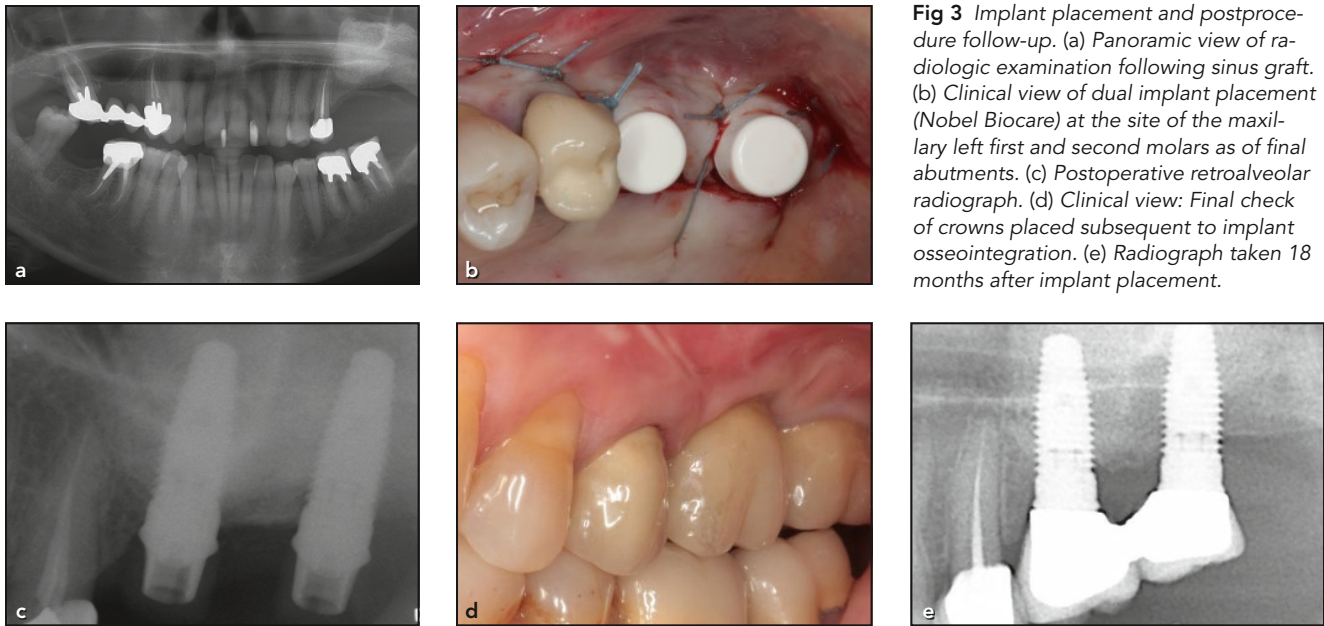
Implant placement and postprocedure follow-up. (a) Panoramic view of radiologic examination following sinus graft. (b) Clinical view of dual implant placement (Nobel Biocare) at the site of the maxillary left first and second molars as of final abutments. (c) Postoperative retroalveolar radiograph. (d) Clinical view: Final check of crowns placed subsequent to implant osseointegration. (e) Radiograph taken 18 months after implant placement.
